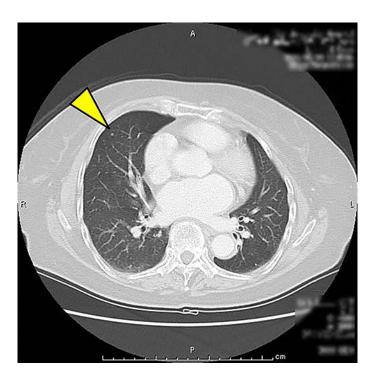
Computed tomography showed a small pulmonary nodule (arrowhead; tumor diameter: 3 mm).
